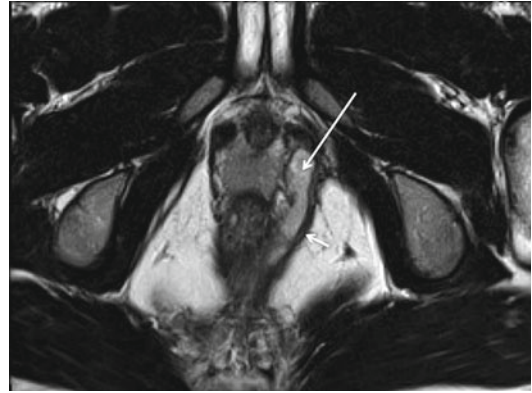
Axial T2-weighted MRI in a patient with a left-sided supralelevator extension (*long arrow*). Note the extension is supralelevator because it lies medial to the left levator plate (*short arrow*)
